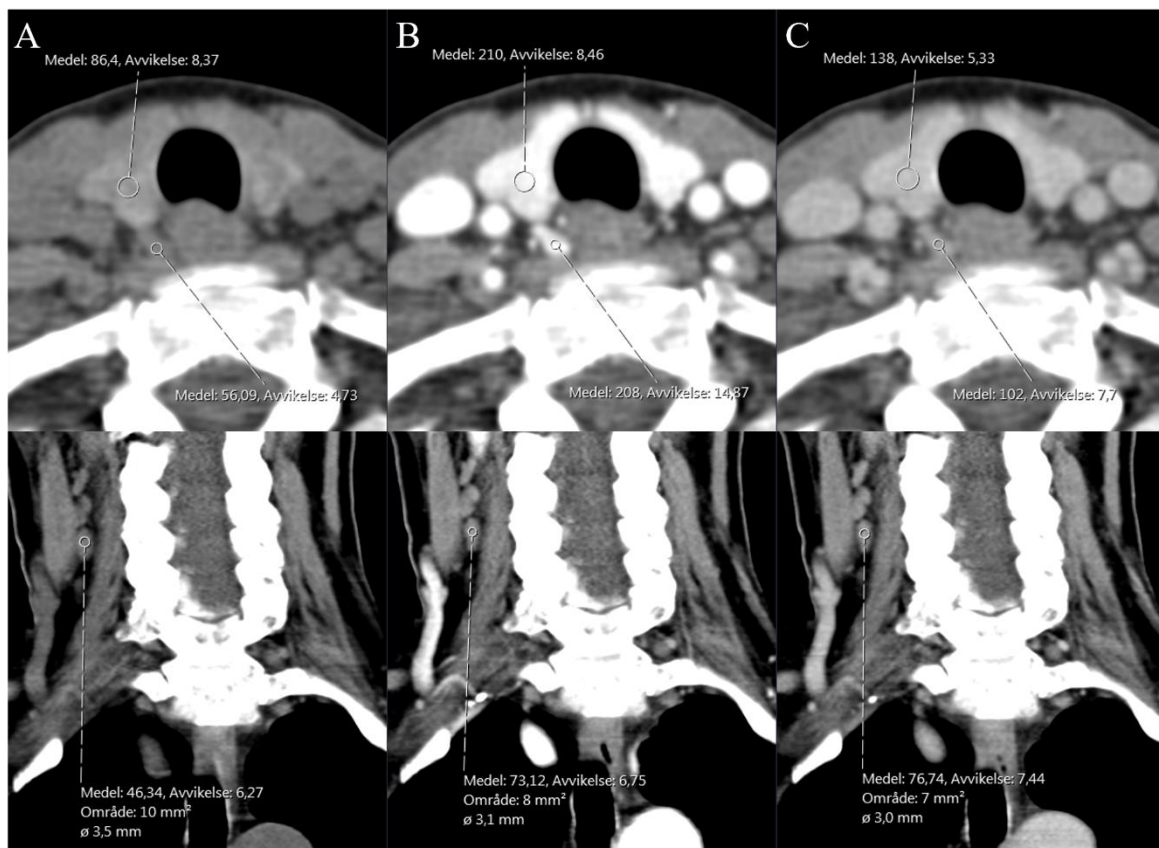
Transaxial (upper row) and coronal (lower row) CT images in native (A), arterial (B) and venous (C) phases from a representative patient in cohort II. The circles indicate the anatomical structure where the CT attenuation values were measured, the thyroid and parathyroid adenoma in the upper rows and a lymph node in the lower row.
